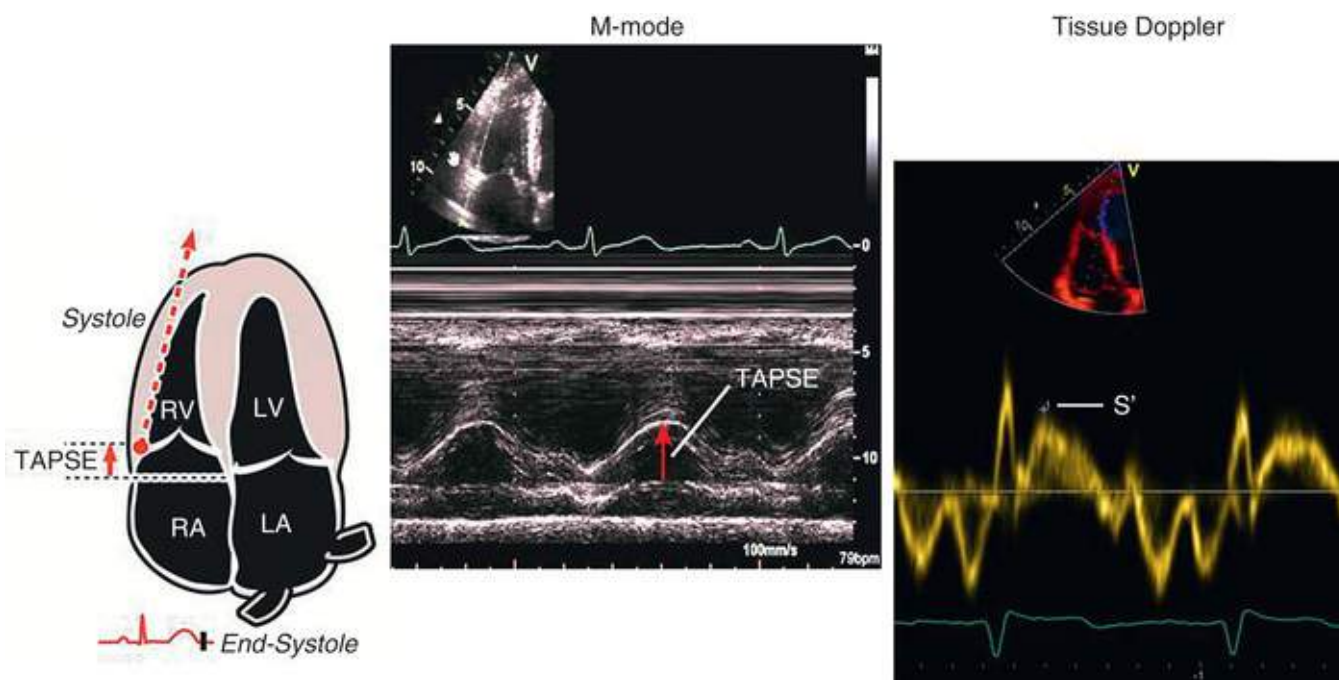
M-mode and Doppler tissue imaging (DTI) measurements of RV systolic function. Left and middle panels, On M-mode, the tissue annular plane systolic excursion (TAPSE) can be measured. Right, DTI is used to map tricuspid annular motion, where S' is the analogous measurement to TAPSE.
